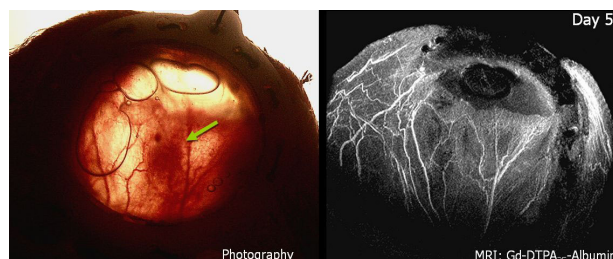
Optical photography using the macro setting on a Minolta Z2 digital camera compared to a maximum intensity projection of the MRI scan using the intravascular contrast agent. The thickness of the window containing the tumor at this stage was approximately 1.3 mm.
